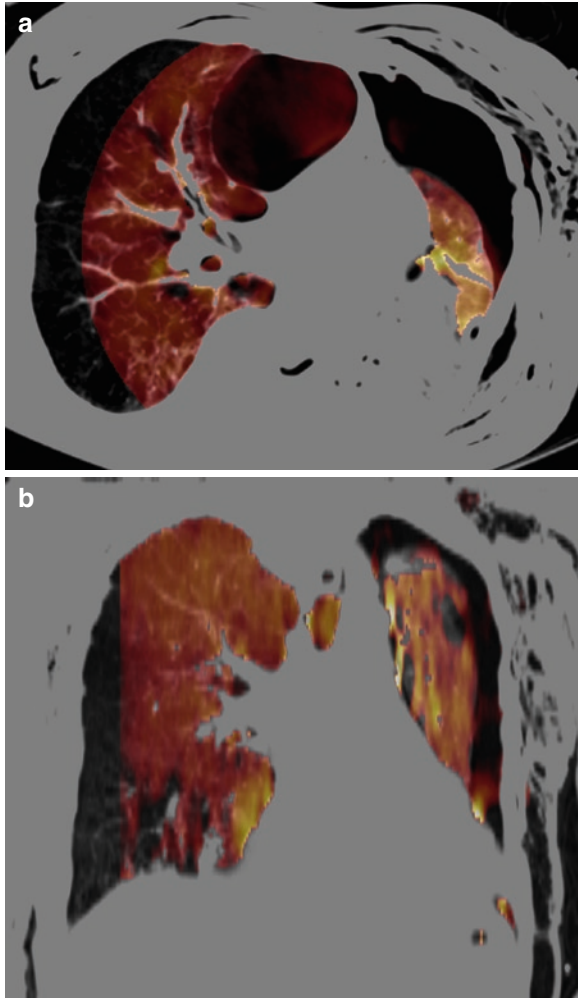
Forty-nine year-old female patient with postinfectious bronchilitis. Transversal CT image in lung window with superimposed color-coded xenon distribution map (a) shows slightly hypoattenuating lobules in the right lower lobe as well as small nodular opacities and branching tubular subpleural structures consistent with bronchiolitis. A ventilation defect in the right
